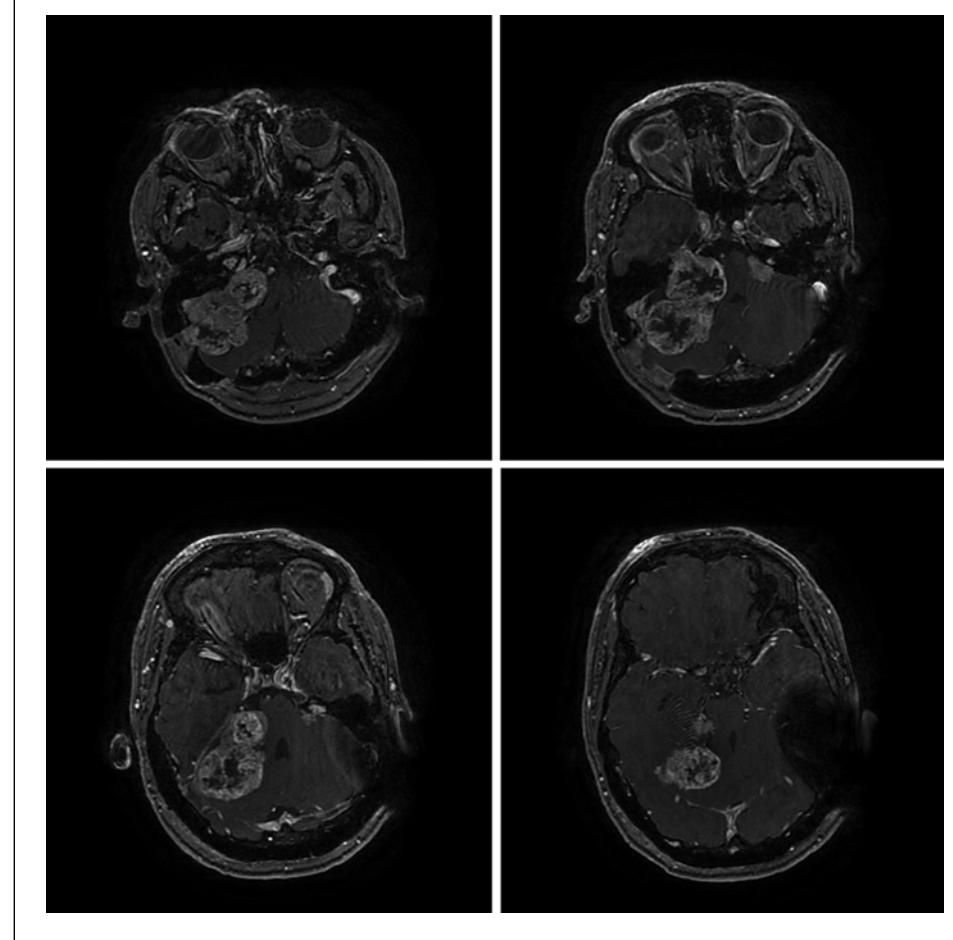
T1 contrast MR imaging appearances of CN VIII schwannoma in the cerebellopontine angle (CPA) in a 25-year-old male. Artifacts caused by the presence of cochlear implant.
